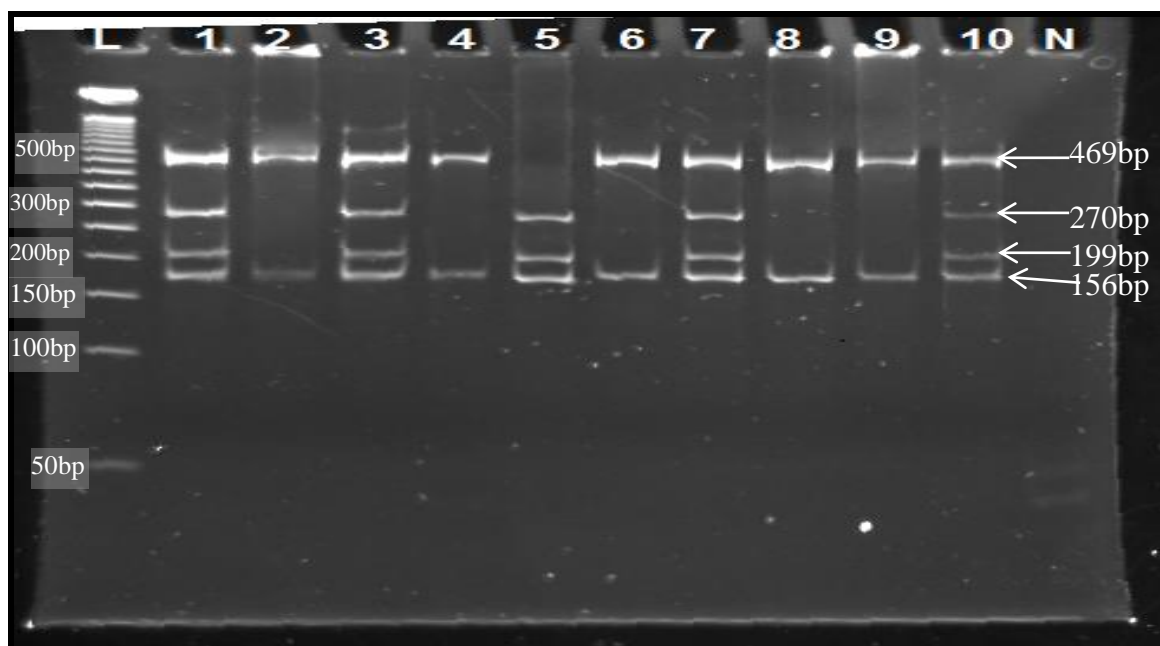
Genotyping of rs1530440 by the designed PCR-RFLP method . (lanes : N = internal negative control ; L=50 bp step ladder ; 1,3,7and 10= CT genotype ; 5 = TT genotype ; 2,4,6,8 and 9 = CC genotype .
